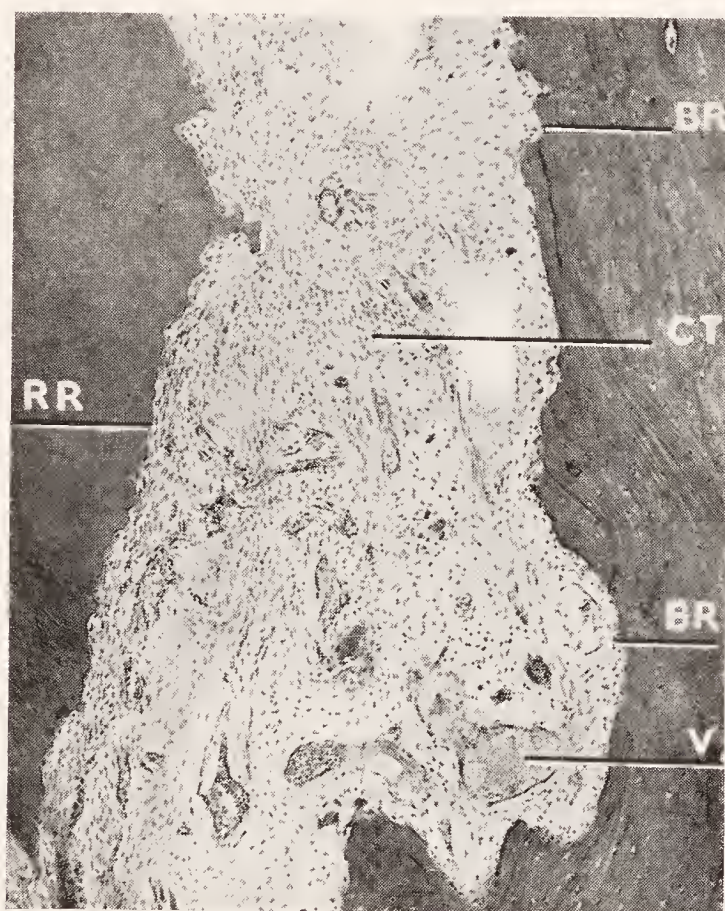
High magnification of a portion of the root surface near the apex in Fig. 268. RR, resorbed dentin surface; CT, loose connective tissue; V, bloodvessels; BR, bone resorption.
